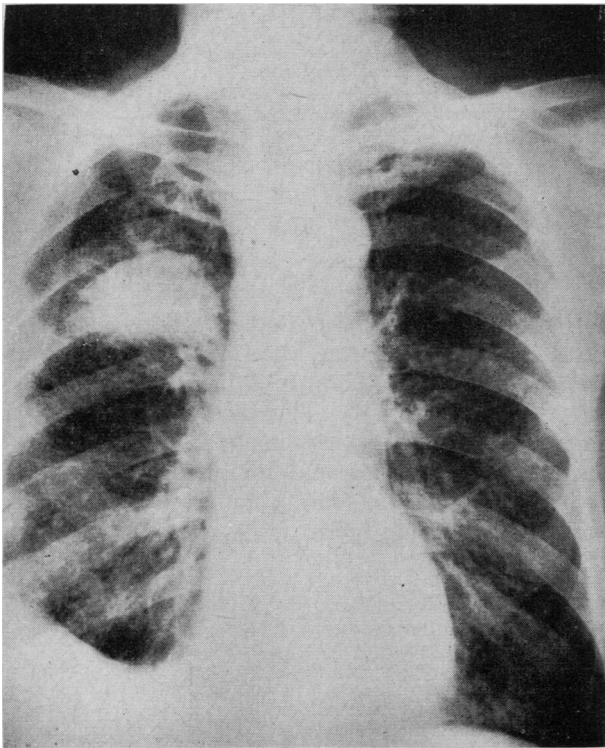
Posteroanterior chest radiograph demonstrating small right apical pneumothorax resulting from attempt to biopsy right upper lobe density.
